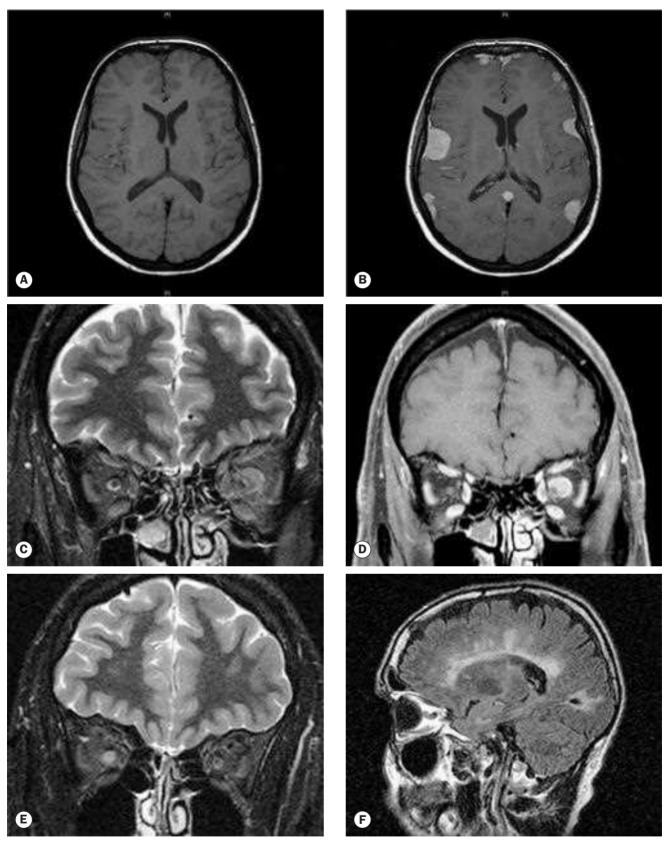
Enhancement techniques. (A) Pre-contrast axial T1-weighted MR image of the brain in a patient with neurofibromatosis type 2 and multiple meningiomas; (B) gadolinium enhancement of the tumours; (C) coronal STIR image showing an intermediate signal intensity mass surrounding the left optic nerve consistent with an optic nerve sheath meningioma compared to STIR; (D) T1-weighted fat saturated coronal image of the same patient as (C) showing avid homogeneous enhancement of the meningioma; (E) coronal STIR image of right retrobulbar neuritis showing a high signal within the optic nerve with enlargement of the nerve sheath complex; (F) sagittal FLAIR image showing multiple periventricular plaques of demyelination *(Courtesy of N Sibtain – figs C–F)*
